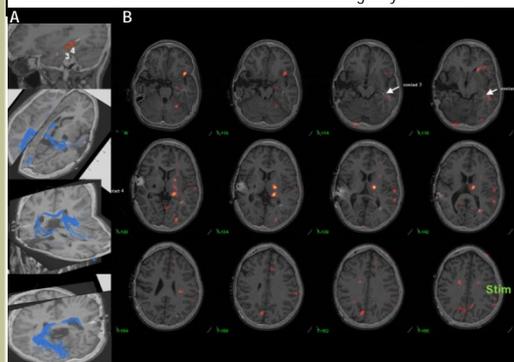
Static Activated SPECT. (A) Pre-implantation tractography model of 3.75mm radius 'seed volume of interest' surrounding depth electrode implant sites for contacts 3-4 on co-registered DTI-SPGR MRI. (B) Post-implantation validation of tractography model using static subtracted activated SPECT co-registered to CT-MRI. Transient hyperperfusion-related changes are seen collapsed as a single snapshot while delivering a train of 12 brief pulses through depth contacts 3-4. The activated InSPira SPECT dataset was subtracted from a baseline study.
